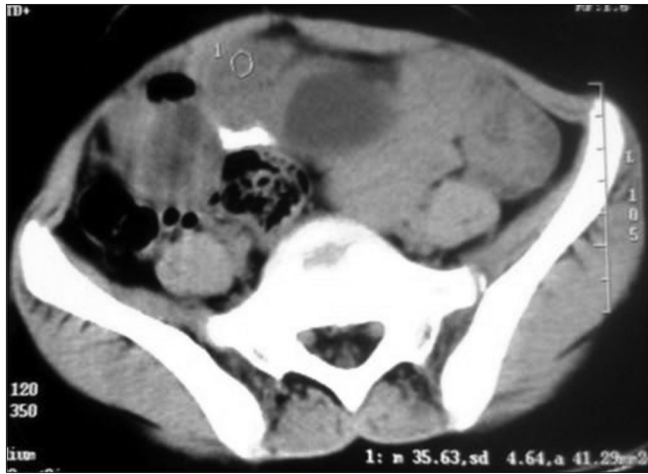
Computed tomography scan whole abdomen showing a pocket of collection in the right paraumbilical level extending to umbilicus
